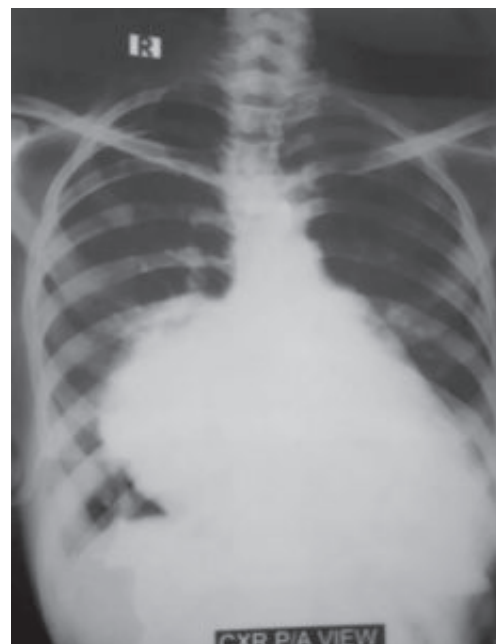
Pre operative chest X-ray P/A view showing giant left atrium
